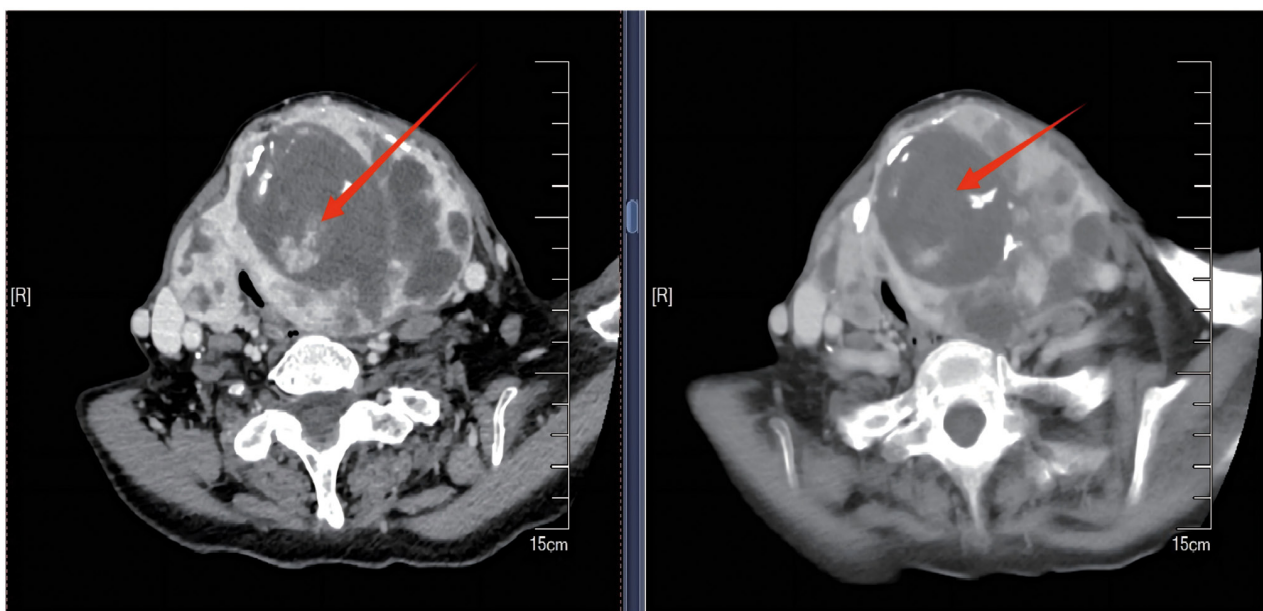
Contrast-enhanced CT findings of the thyroid mass. Representative axial contrast-enhanced CT images of the neck showing a large heterogeneous mass arising from the left thyroid lobe, with internal low-attenuation areas and calcific foci. The mass caused marked compression, narrowing and rightward displacement of the trachea. The arrows indicate representative portions of the thyroid mass. CT, computed tomography.
